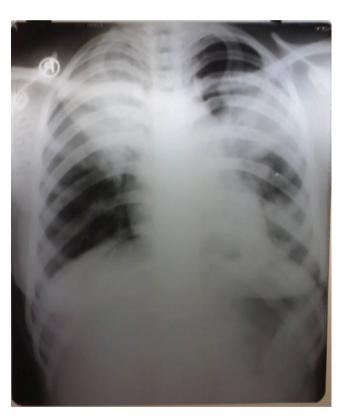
Chest X-ray showing bilateral pneumonic consolidation.
